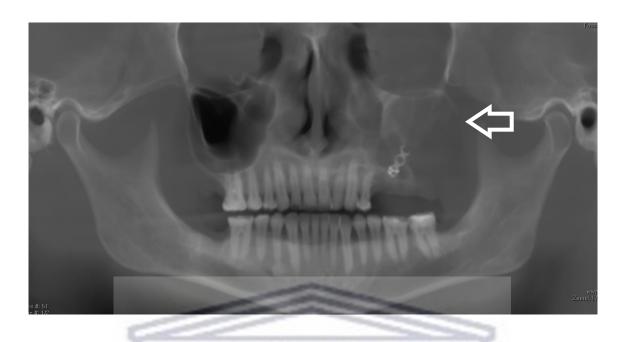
Four month post-operative pantomograph CBCT of same patient in Figure 12 showing recurrence of residual cyst in left maxilla post enucleation.
